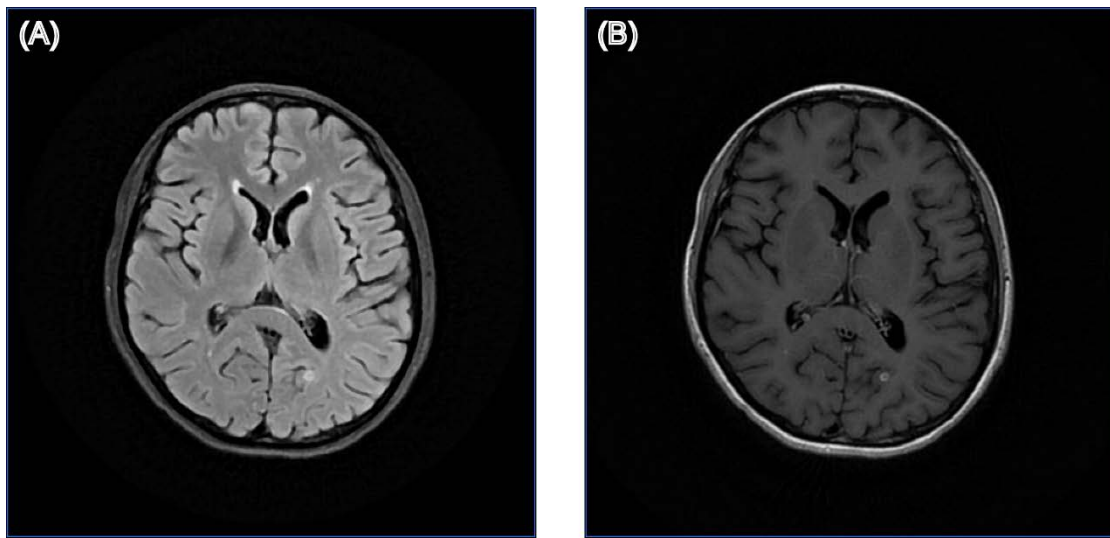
Structural brain MRI images of patient 21. (A) T2-weighted fluid-attenuated inversion recovery (T2-FLAIR) image; (B) Gadolinium-enhanced T1-weighted (Gd-T1w) image.
